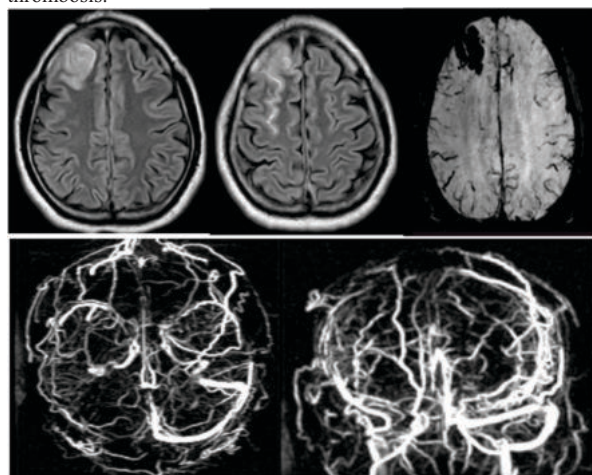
a) Axial FLAIR image showing high signal intensity in cortical and subcortical white matter of right frontal lobar region. b) Axial FLAIR image showing sulcal hyperintensities in right frontal region suggestive of subarachnoid hemorrhage. c) Axial GRE sequence showing blooming. d) And e) MR venograms showing loss of flow related signal intensity involving superior sagittal, right transverse, right sigmoid sinuses and adjacent cortical veins suggestive of thrombosis.
